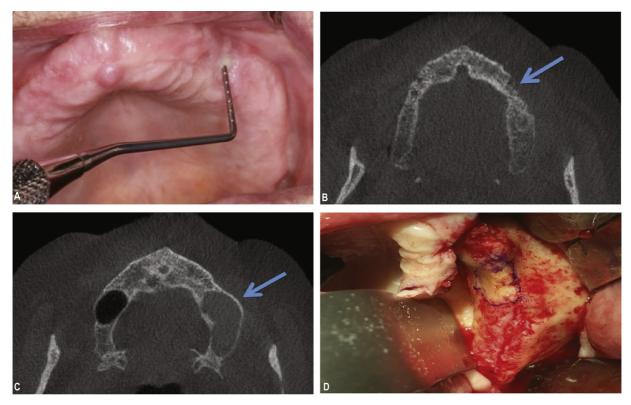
Example of nonexposed medication-related osteonecrosis of the jaw. A, A patient receiving high-dose denosumab presented with pain in an apparently normal edentulous left maxilla. A droplet of pus was seen on palpation and bone was probed through a fistula. B, C, Cone beam computed tomography showed sequestrum at regions 24 and 25 (*arrow*) and infection in the left maxillary sinus. D, Perioperative view showing osteonecrosis outlined on the bone surface. Uneventful healing was accomplished. (Images courtesy of Dr. Morten Schiødt, University Hospital of Copenhagen. Published with the permission of the Danish Dental Journal; Schiødt M, et al. Medicinrelateret osteonekrose i kæberne—oversigt og retningslinjer. *Tandlægebladet*. 2015;119:918-930.)
